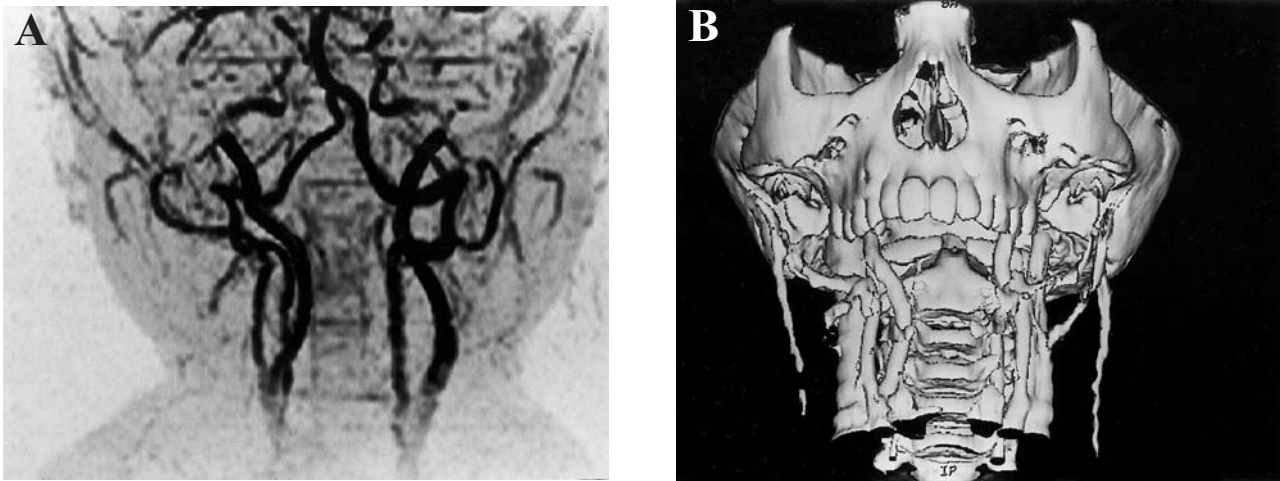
Typical findings of vascular anomalies in patient no. 5 shown by CTA (B) and MRA (A).
